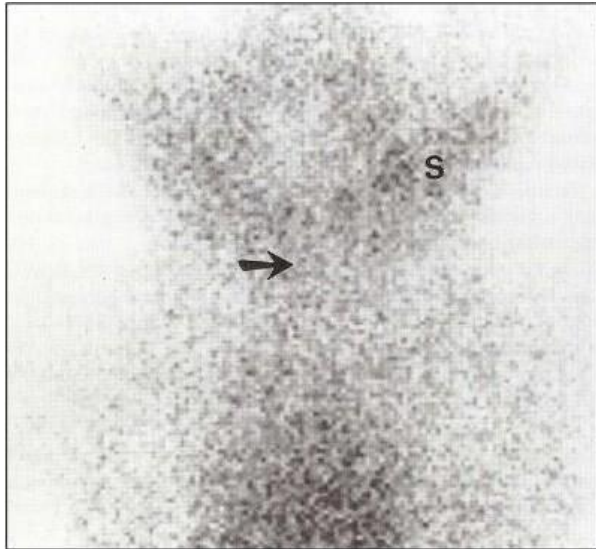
99mTc-pertechnetate thyroid scintigraphy in a newborn with thyroid aplasia. No thyroid tissue is seen in the neck (arrow). Activity is seen in the salivary gland (S).
